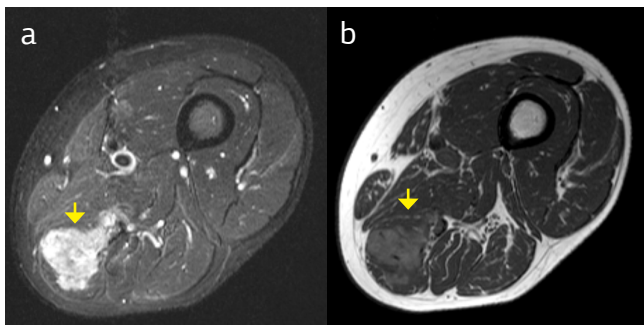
MRI shows a lesion, proximal portion of the biceps femoris muscle with high signal intensity on T2W1 (a) and low signal intensity on T1W1 (b).
